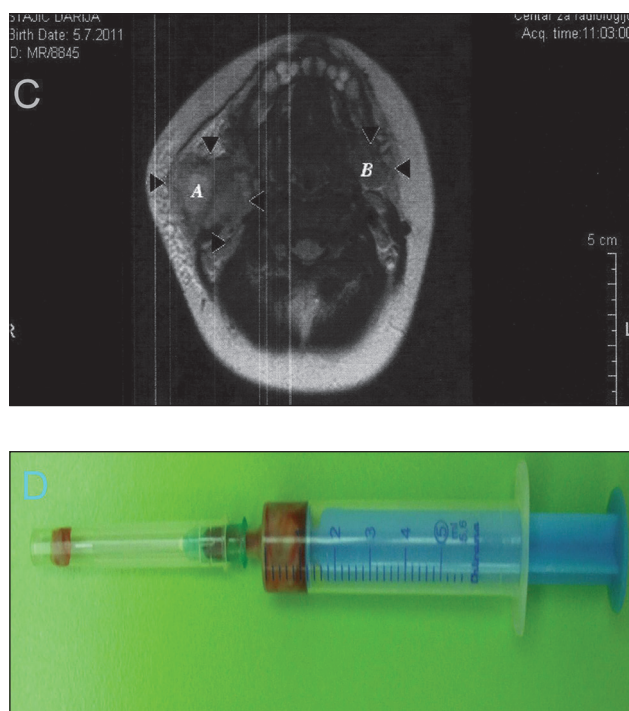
A. Diffuse interstitial infiltrates in lungs. B. Clinical feature of abscessus of right parotid gland. C. MRI scanning of parotid glands. Right parotid gland without malformations but with 37x35x25mm size abscess, no abnormalities of the left parotid gland were seen. D. Pus from parotid gland
